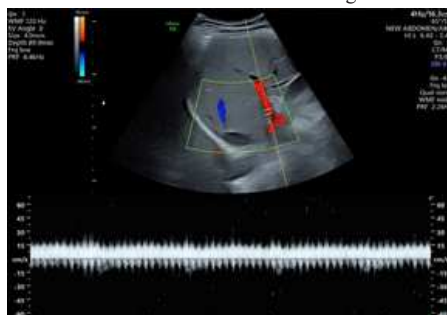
The spectral color Doppler image showed normal color uptake with a normal hepatopetal flow pattern and normal respiratory variation, but with a reduced flow velocity of 11.6 cm/sec. The portal vein diameter measured 14.5 mm, indicating dilation.
